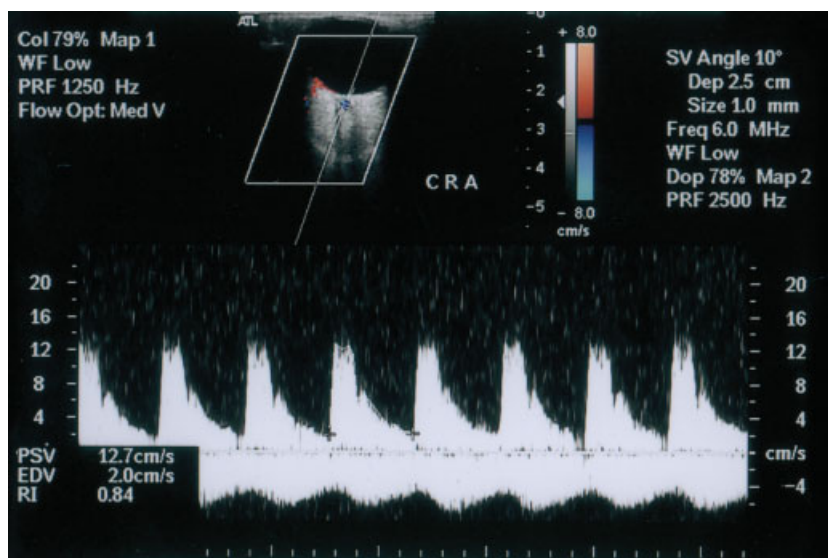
Color duplex sonogram of a central retinal artery (CRA) in a patient with obstructive sleep apnea syndrome shows a peak systolic velocity (PSV) of 12.7 cm/second and a resistance index (RI) of 0.84.
